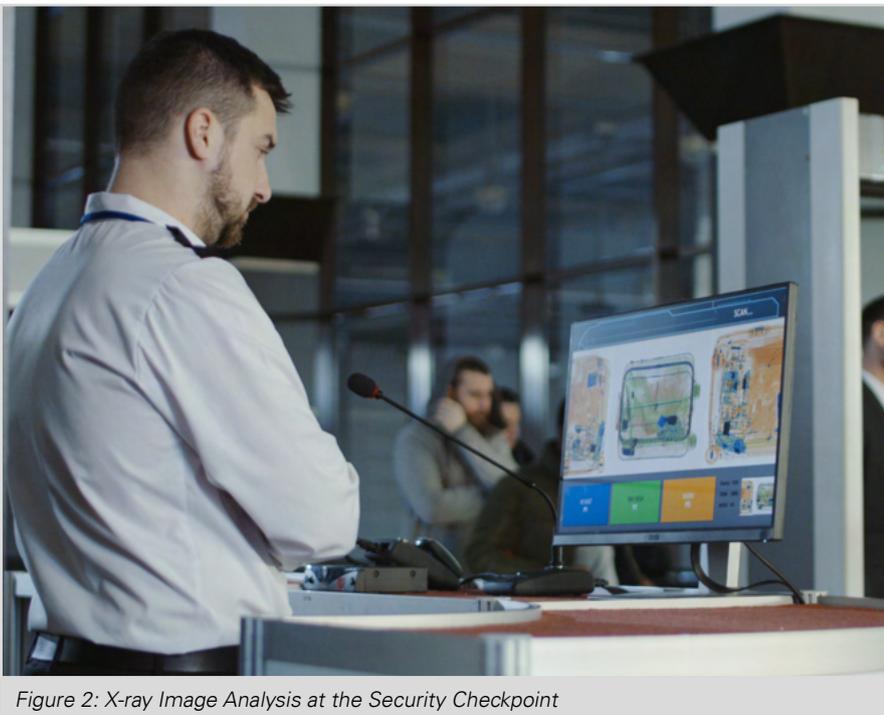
X-ray Image Analysis at the Security Checkpoint
